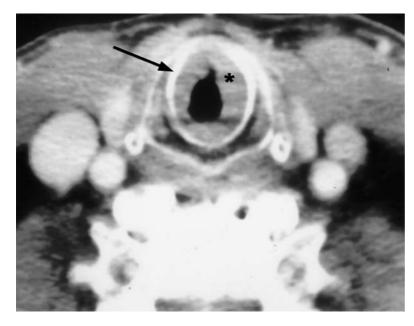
Subglottic stenosis. Axial computed tomography scan demonstrates diffuse circumferential thickening of the submucosa in the subglottic space (asterisk). Note the normal cricoid cartilage (arrow).
